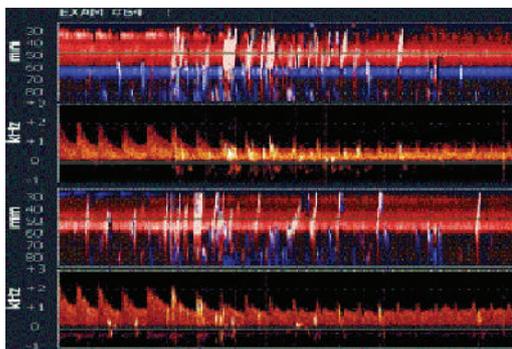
Power motion-mode transcranial Doppler imaging in a patient with a 12 mm diameter patent foramen ovale. This defect was first diagnosed by bilateral power motion-mode transcranial Doppler and subsequently closed with a CardioSEAL[®] device (NMT Medical, Boston, MA). Note the embolic tracks, shown in white, sloping across the red and blue bands of the displays and the presence of some of these microembolic signals in the spectrograms. Reproduced with permission from Spencer Vascular Technologies, Seattle, WA, USA.
